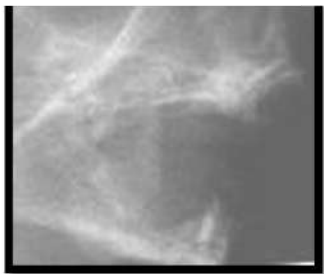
Radiograph of upper and lower jaws of a fetus at the 16th week of I.U showing the initial mineralization of deciduous incisors
